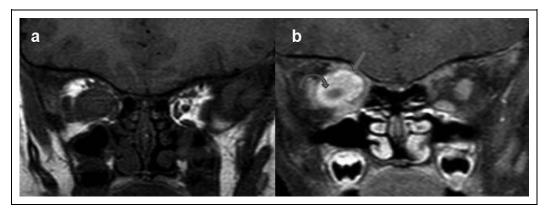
Magnetic resonance imaging (MRI) of a mass lesion originating from the right optic nerve sheath is seen. (A) The lesion is hypointense on TI-weighted images. (B) Following contrast administration, unenhanced optic nerve (curved arrow) can be clearly distinguished from the strongly enhanced mass lesion (straight arrow).
